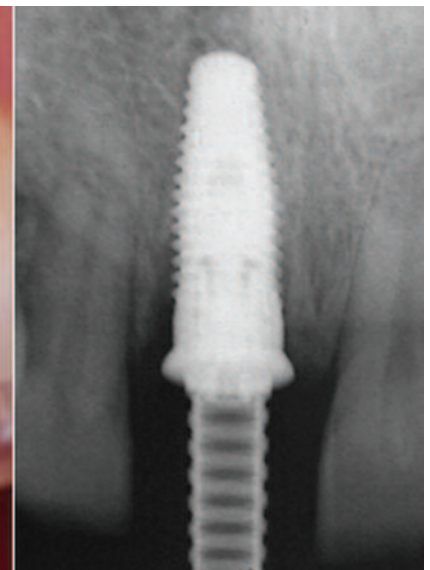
Registration of the position of the implant neck by means of an acrylic template (left). Radiographic control of the fit of the teflon cylinder screwed onto the implant (right).
